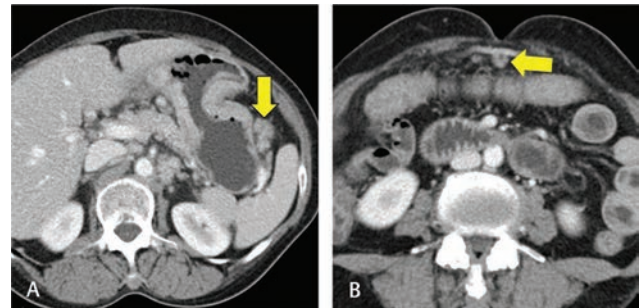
Station 4d/4sa. Axial computed tomography images in venous phase (A) and (B) show enlarged lymph nodes along short gastric arteries (station 4sa, arrow in A) and right gastroepiploic artery (station 4d, arrow in B).
